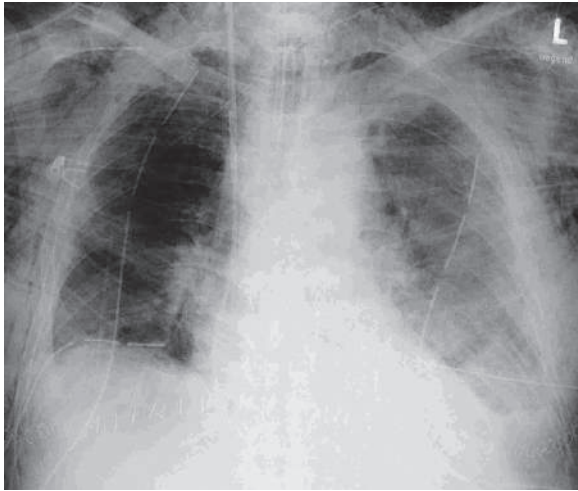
Anteroposterior plain chest radiograph of a patient with subcutaneous emphysema shows air that surrounds the pectoralis muscle fibers bilaterally
